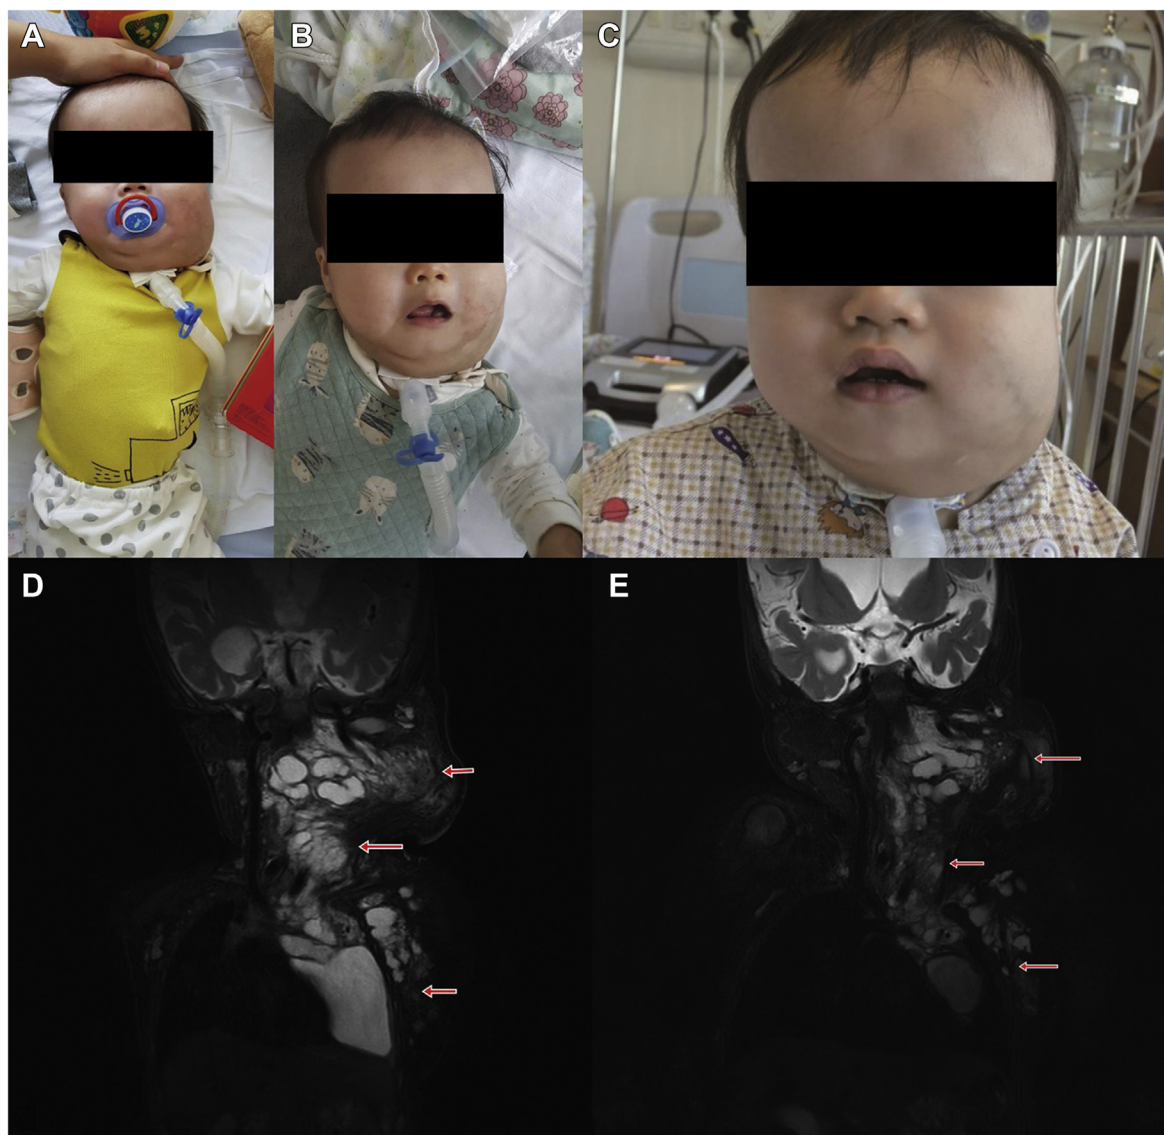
Serial clinical photographs of patient 1 showing a cervicofacial lymphatic malformation (LM) at the initiation of sirolimus (A), at 2 months of administration (B), and 6 months later (C). Coronal T2-weighted magnetic resonance imaging (MRI) of patient 1 at the beginning of therapy (D) and at 1 year of sirolimus therapy (E).
